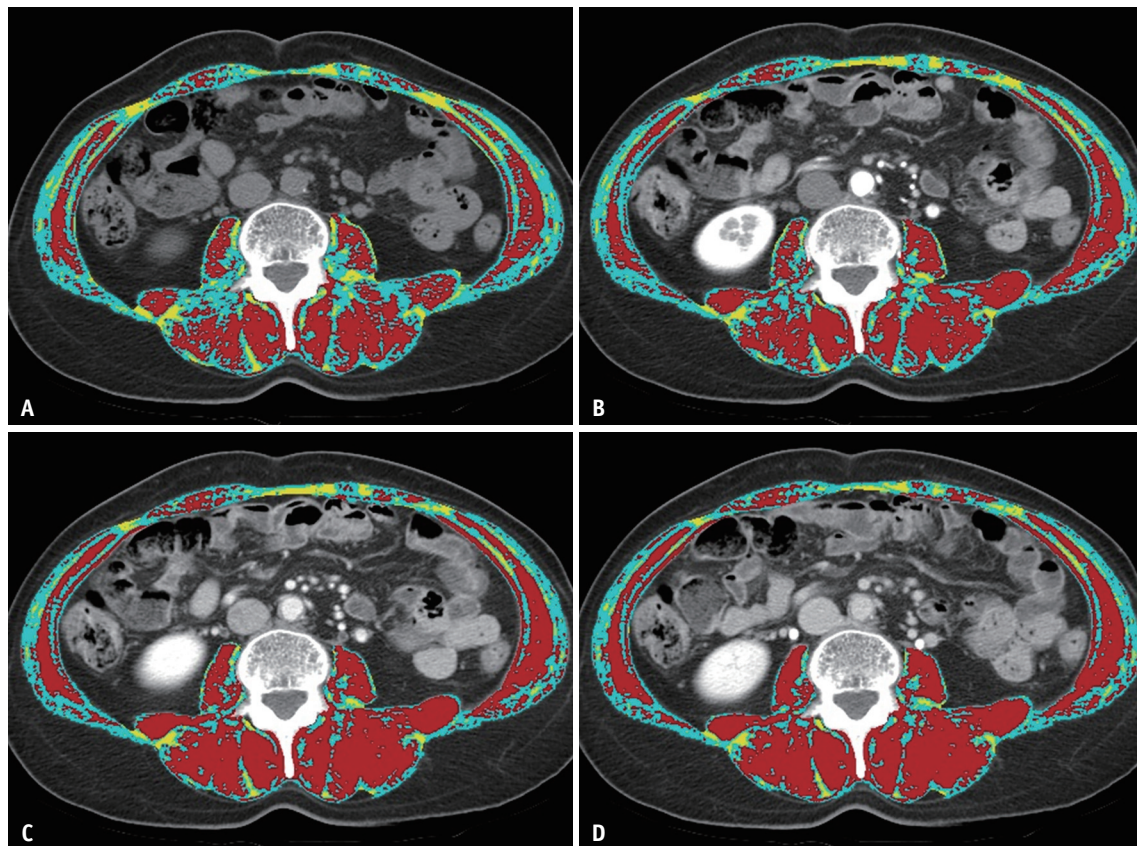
Muscle quality maps for the unenhanced phase (A), arterial phase (B), portal phase (C), and delayed phase (D) CT images. Areas in red represent the normal attenuation muscle area (threshold: from 30 to 150 HU) and those in cyan represent the low attenuation muscle area (threshold: from -29 to 29 HU). HU = Hounsfield unit
